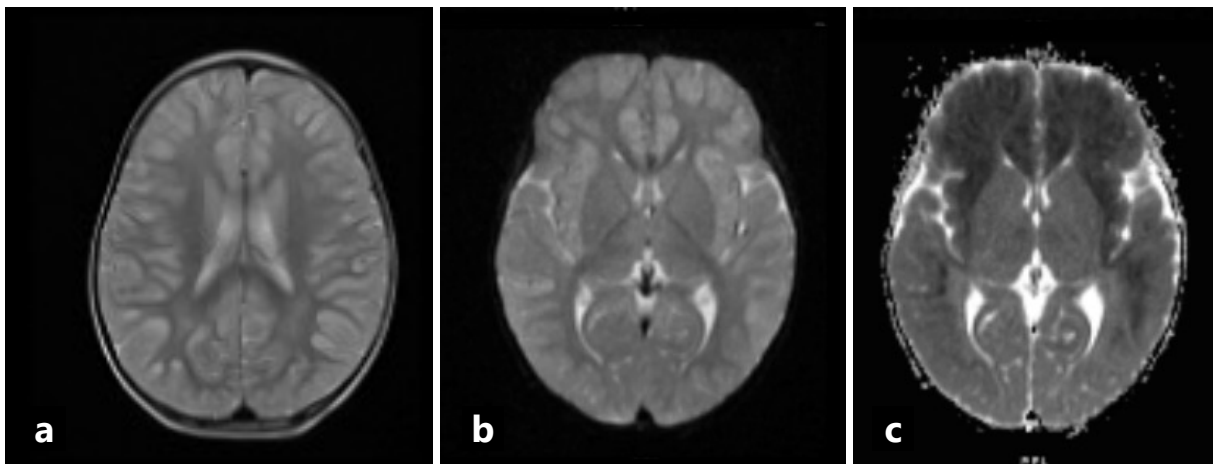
Non-enhanced MRI brain of a 2-year-old boy with hyperammonaemia, presenting with seizures. (a) A T2 weighted sequence shows increased T2 signals in the bilateral subcortical white matter. (b) DWI and (c) ADC images show wavy bands of restricted diffusion at the cortical-subcortical junction of the insular regions (also known as the deep sulcus sign).*
